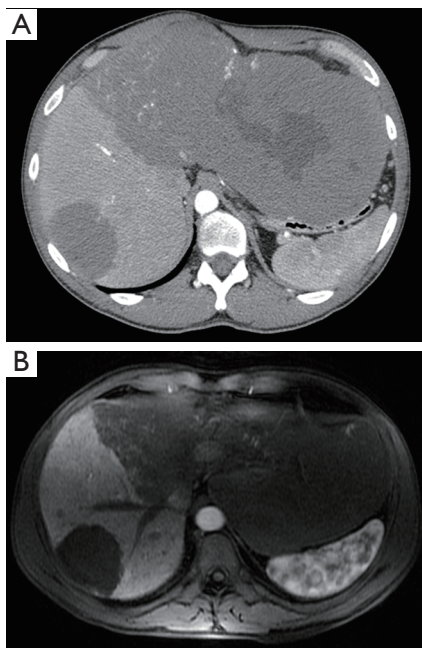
(A) Computed tomography (CT) revealed the presence of giant mass in the left lobe of the liver that causes gastric compression, and multiple similar lesions in the right lobe; (B) magnetic resonance imaging (MRI): the right anterior and posterior hepatic veins are visualized.
